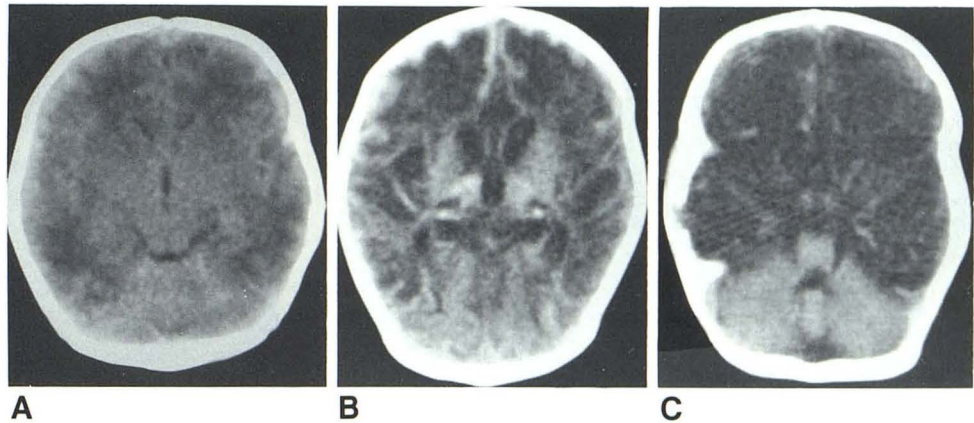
Case 2. End-stage CT findings of neonatal HSE. At autopsy thin remnants of brain parenchyma separated multiple proteinaceous fluid-filled spaces indicative of cystic encephalomalacia. Hemorrhagic necrosis with focal dystrophic calcification was present in thalami and some of parenchymal remnants. (Cf. figs. 1B and 1C).
